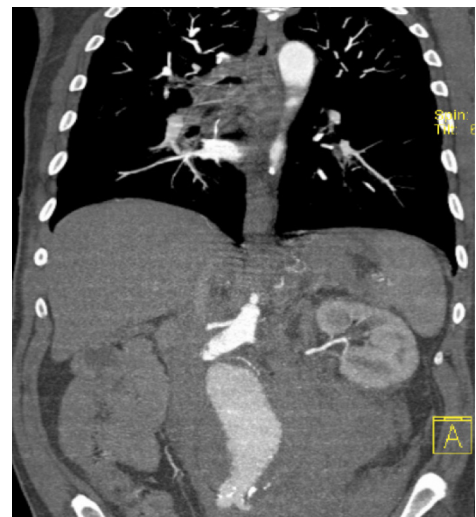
A coronal CT scan view
